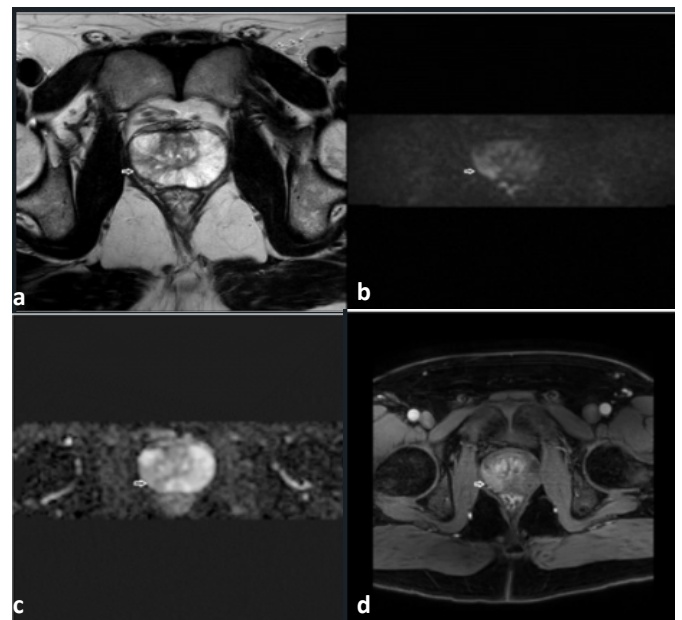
52-year-old patient with PSA 9.4 ng/ml, right peripheral zone hypointense area on T2 (a), hyperintense on DWI (b), hypointense on ADC (c), early arterial phase contrast enhancement in dynamic contrast images (d) PIRADS 2 lesion. Fusion biopsy result was compatible with prostatitis
